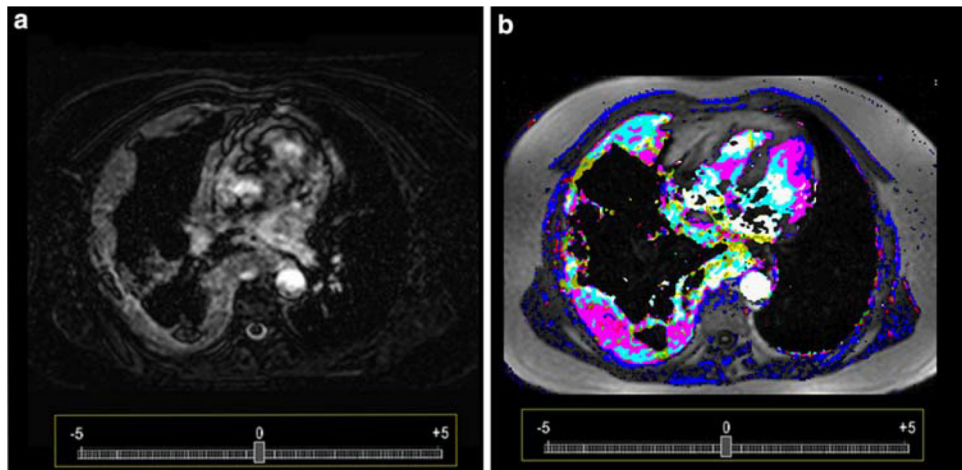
Subtraction images (a) presenting a patient with malignant pleural mesothelioma adjacent to the right chest wall. The high masculinity of the tumor can be already appreciated to most of the tumor tissue. Color code display (b) presents the same tumor vasculature as in a, but on the basis of a post processed dynamic contrast enhanced MRI. Tumor vasculature is better visualized and hyper- and hypo-vascular areas can be well differentiated
